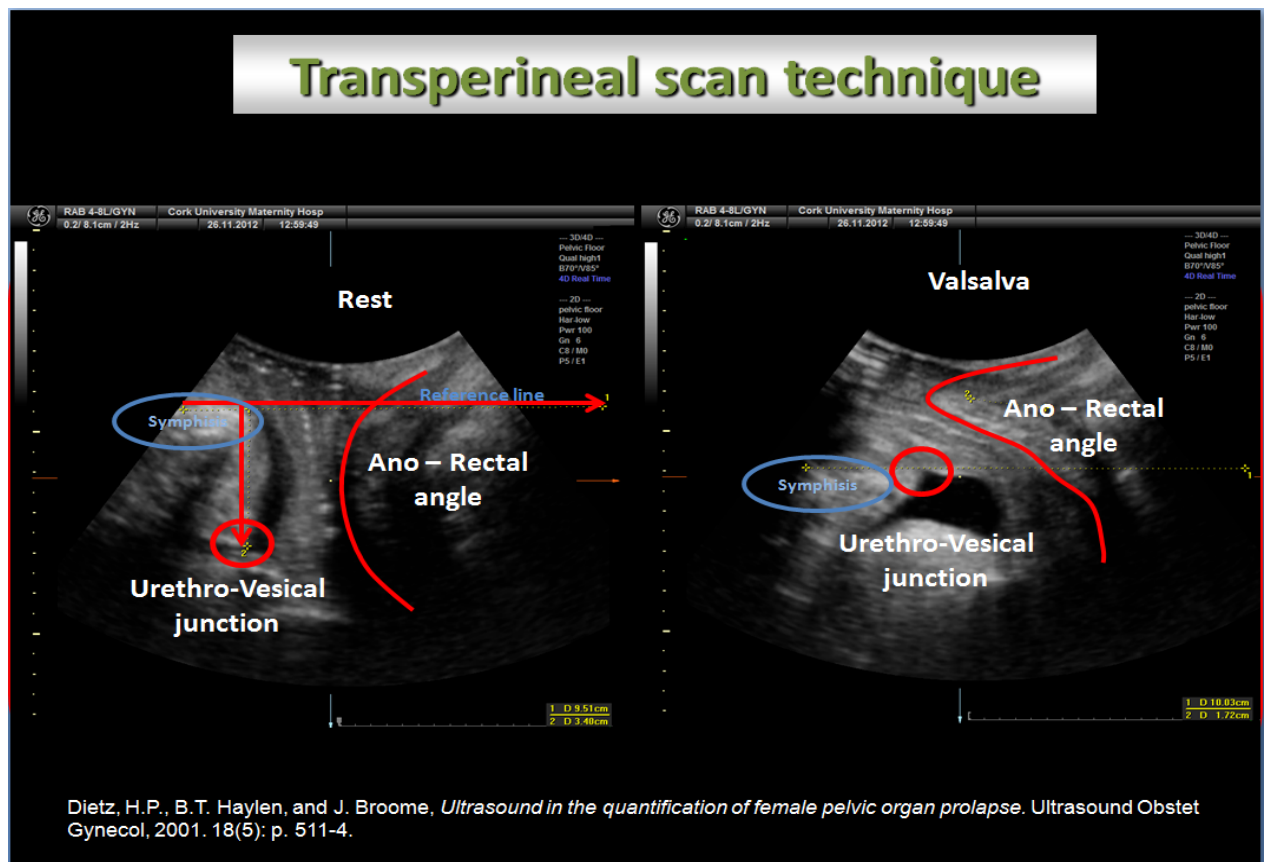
2D - transperineal ultrasound scan
